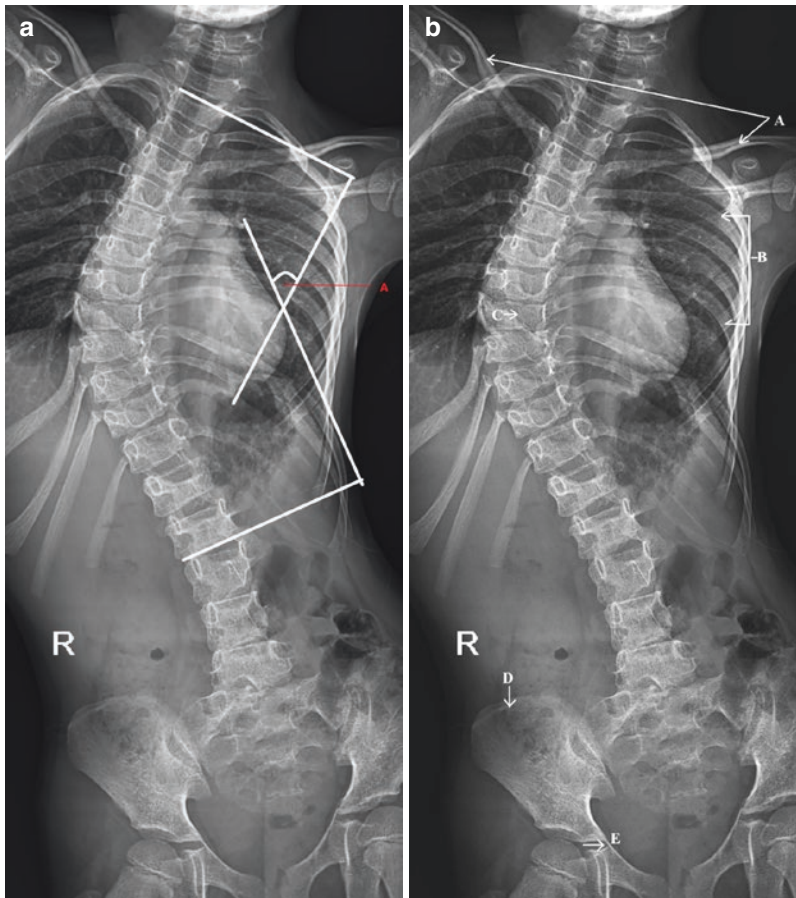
(a) Standing radiograph of the spine (anteroposterior view) showing a single major thoracic scoliosis curve with rightward convexity (dextroscoliosis), extending from T1 to L2 vertebrae; apex of the curve is at T8 vertebra; Cobb angle of the curve (A) is 57° (measured from superior endplate of T1 and inferior endplate of L2 vertebrae). (b) Standing radiograph spine (anteroposterior
